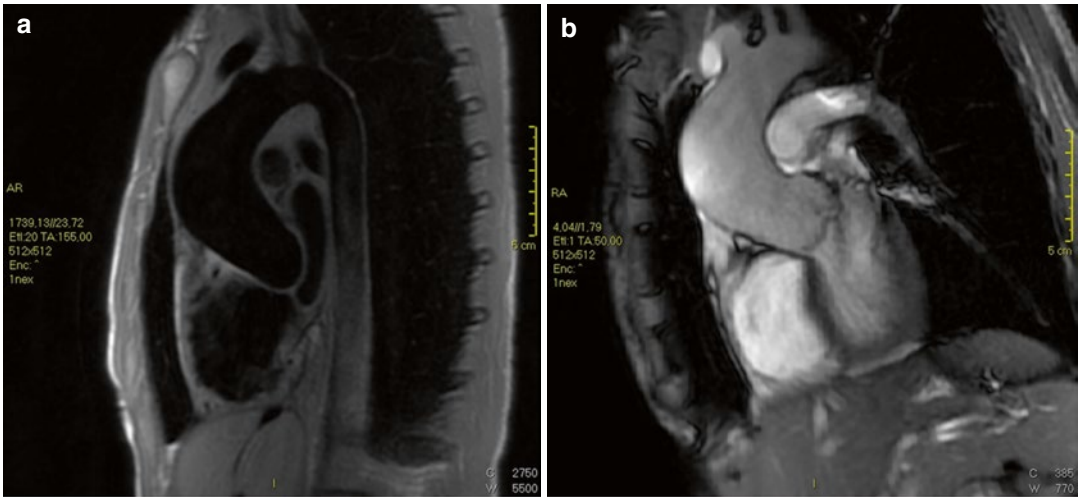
Marfan syndrome and annuloaortic ectasia in a 42-year-old woman. (a) T1-weighted and (b) gradient echo sagittal oblique MRI show a pear-shaped aorta that
